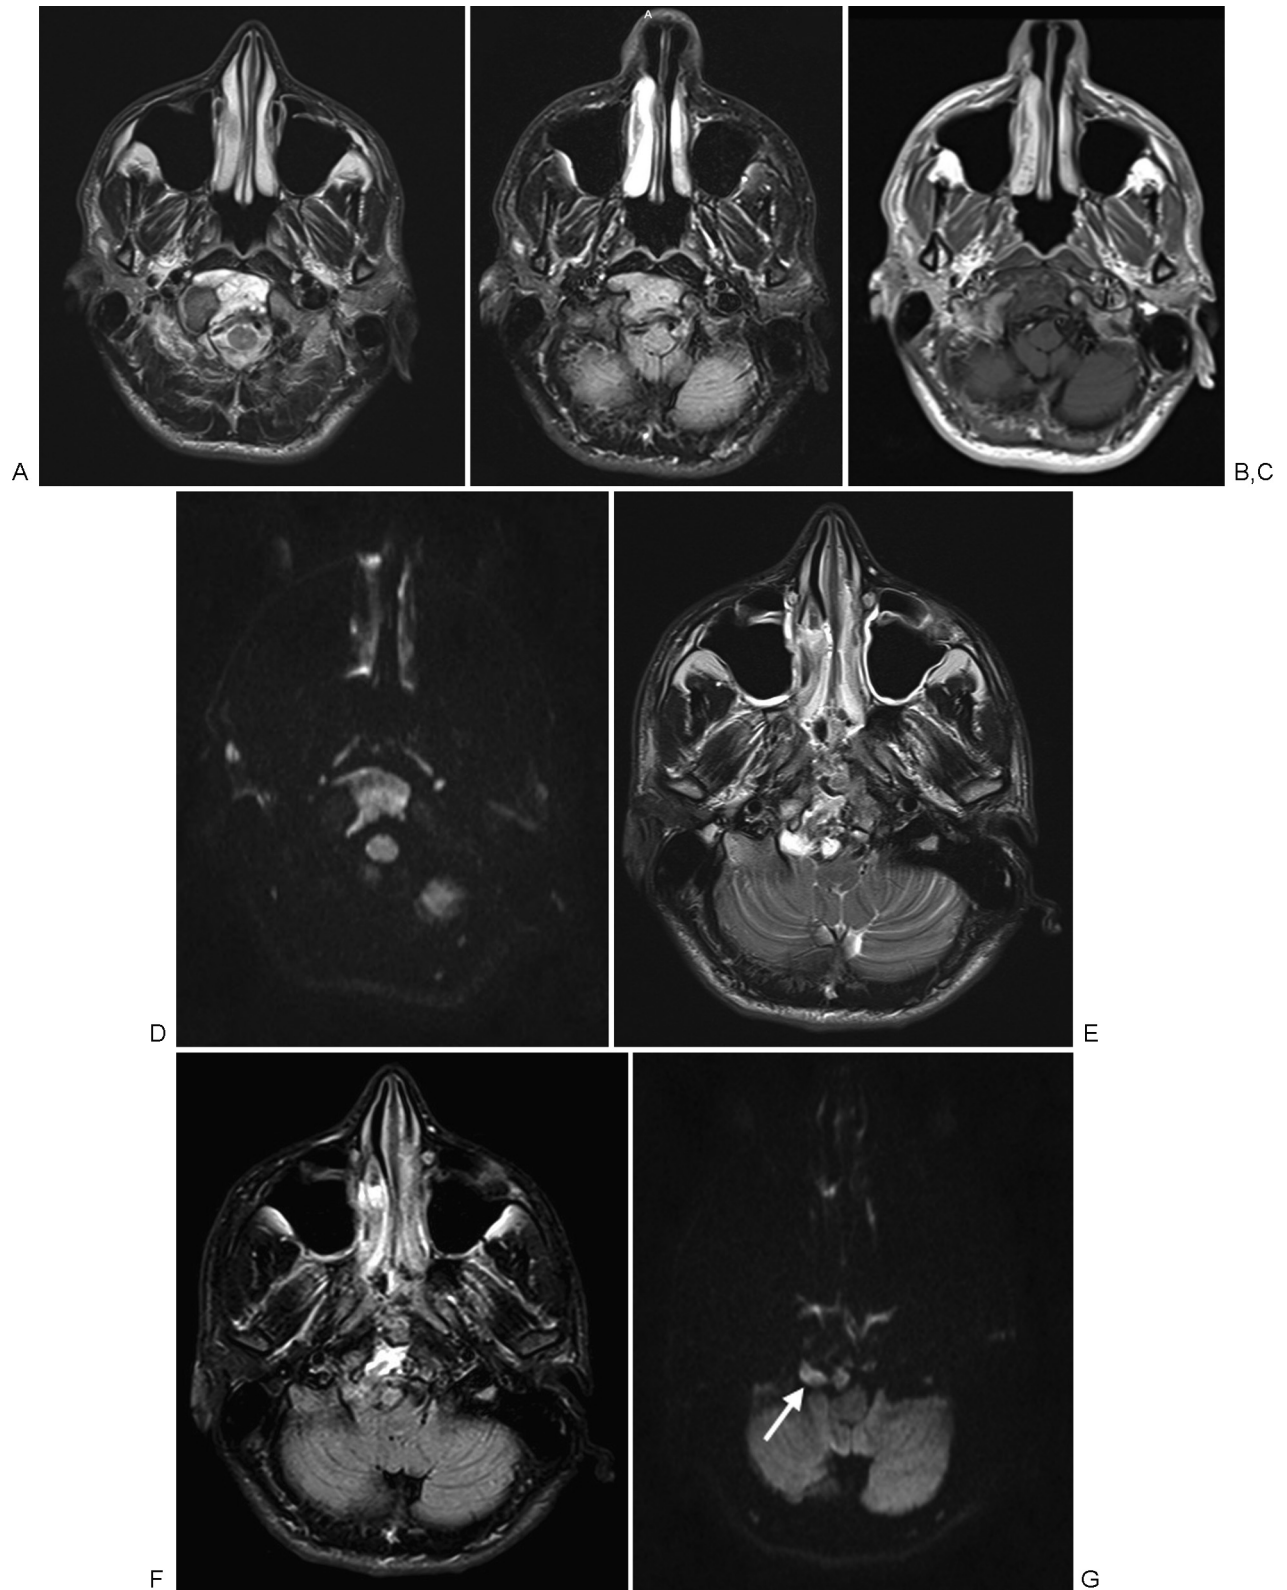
(A–D) Preoperative and (E–G) postoperative magnetic resonance images of a 19-year-old male with typical chordoma. (A) Axial T2-weighted (W) and (B) axial fluid-attenuated inversion recovery (FLAIR) images show a multiseptate mass located at the inferior of the clivus. Axial postcontrast T1W image (C) reveals that the mass has little/no enhancement but is well defined on diffusion-weighted (DW) trace image (D). On the postoperative scan, the residual lesion is much easier to detect on the DW trace image (G) (arrow) than on the T2W (E) and FLAIR (F) images.
